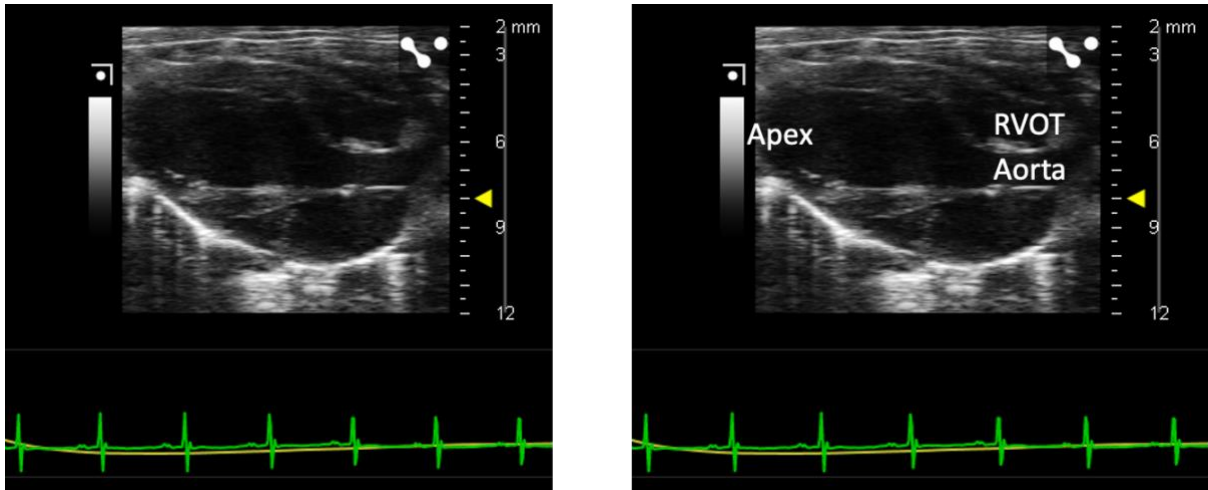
Representation of images captured in parasternal long axis.
